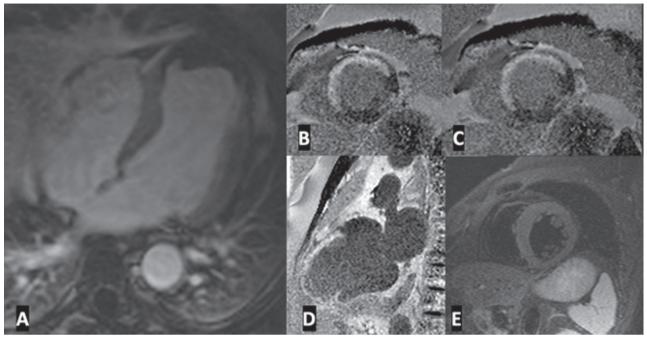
Ischemia. 4Chamber(*A*) Cine MRI (SSFP) shows LV dilatation with thrombus at LV apex. PSIR LGE images (B, C, D) visualize chronic ischemic scar at anterior and diaphragmatic LV wall following vessel distribution (LAD) and ischemic pattern of enhancement. There isn't edema on the STIR sequence (E).
